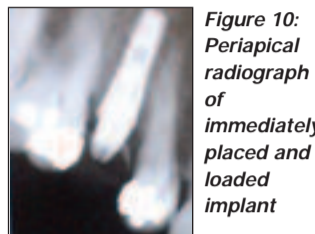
Periapical radiograph of immediately placed and loaded implant
